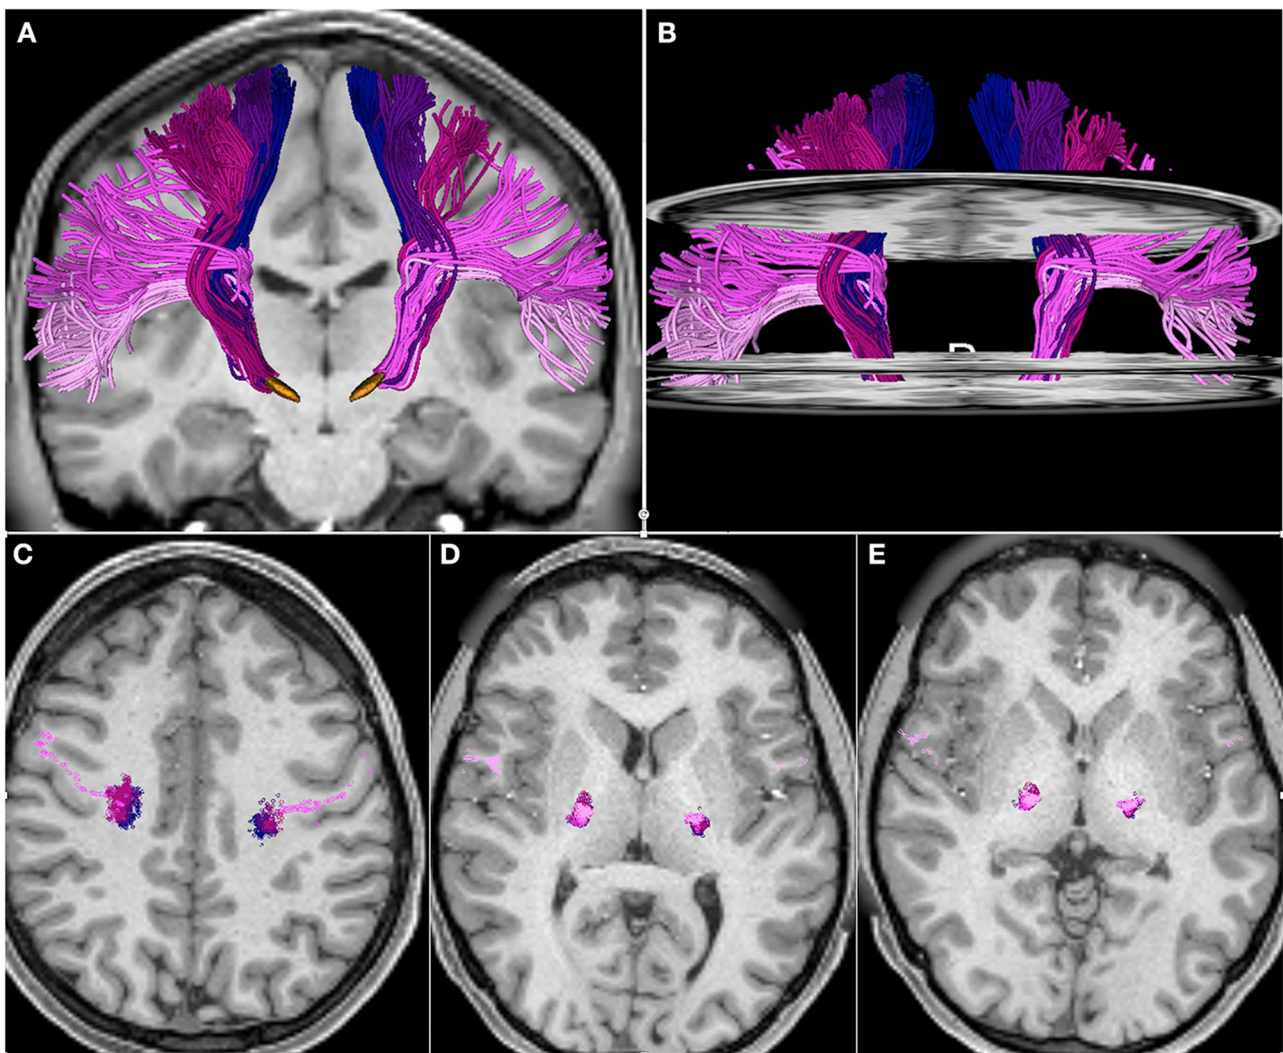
Somatotopic organization of hyperdirect pathway fibers projecting from the primary motor cortex trunk, arm, hand, face, and tongue area. The tracts are displayed on axial and coronal T1-weighted images. (A) 3D anterior view of hyperdirect pathway fibers with 3D models of the subthalamic nucleus (orange). (B) 3D anterior view of hyperdirect pathway fibers with axial T1-weighted images at the level of the corona radiata, internal capsule and zona incerta. (C–E) Intersection of hyperdirect pathway fibers with an axial T1-weighted image at the level of the corona radiata (C), posterior limb of the internal capsule (D), and zona incerta (E). The three axial slices in (B) correspond to the axial images displayed in (C–E). The fibers are colored according to the motor regions: trunk (blue), arm (dark purple), hand (dark pink), face (light purple), tongue (light pink).
